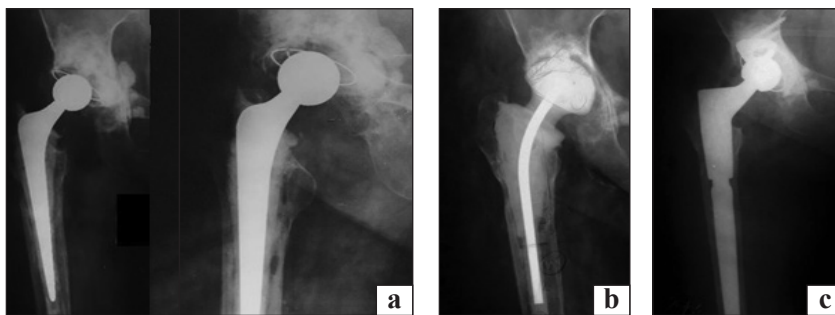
Patient G. Radiographs “before” and “after” surgical interventions: periprosthetic infection of the right hip joint (a); condition after revision intervention and installation of a metal-cement spacer (b) and after revision arthroplasty (c)
